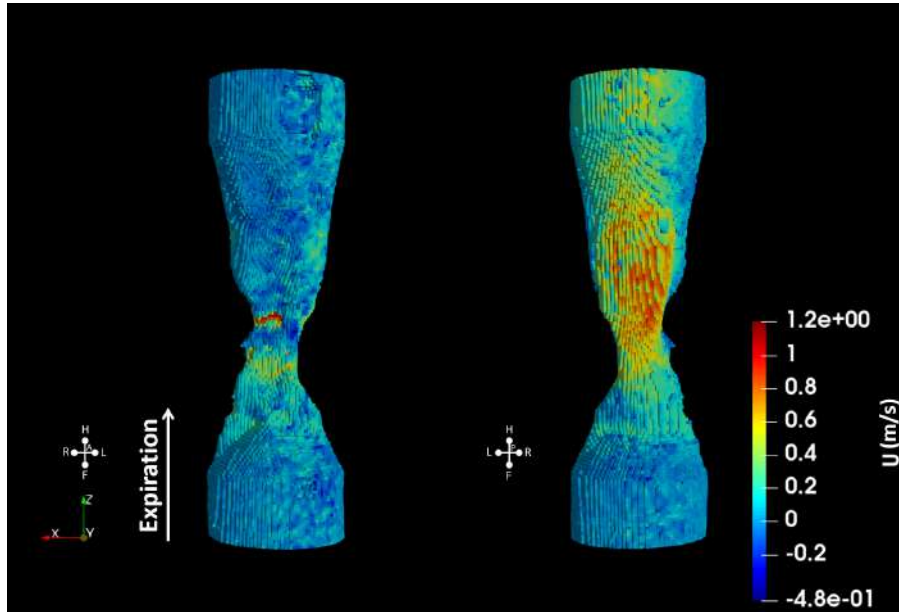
3D model of the pharynx during expiration obtained from 2D PC-MRI as visualized in Paraview (left: front view and right: back view).
